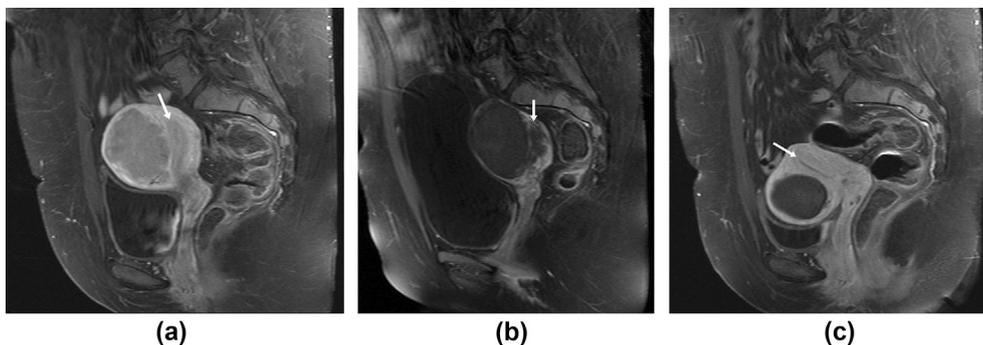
(a) Pre-embolisation sagittal T1-weighted fat-suppressed MRI of a 41-year-old woman with symptomatic leiomyoma showing a posterior-wall leiomyoma with normal enhancement of the endometrium (white arrow). (b) MRI immediately following embolisation shows an ischaemic area of the endometrium (white arrow) seen as an area of non-enhancement anterior to the devascularised leiomyoma. (c) MRI at 3-month follow-up shows full resolution of the ischaemic area (white arrow) with normal enhancement of the endometrium.
